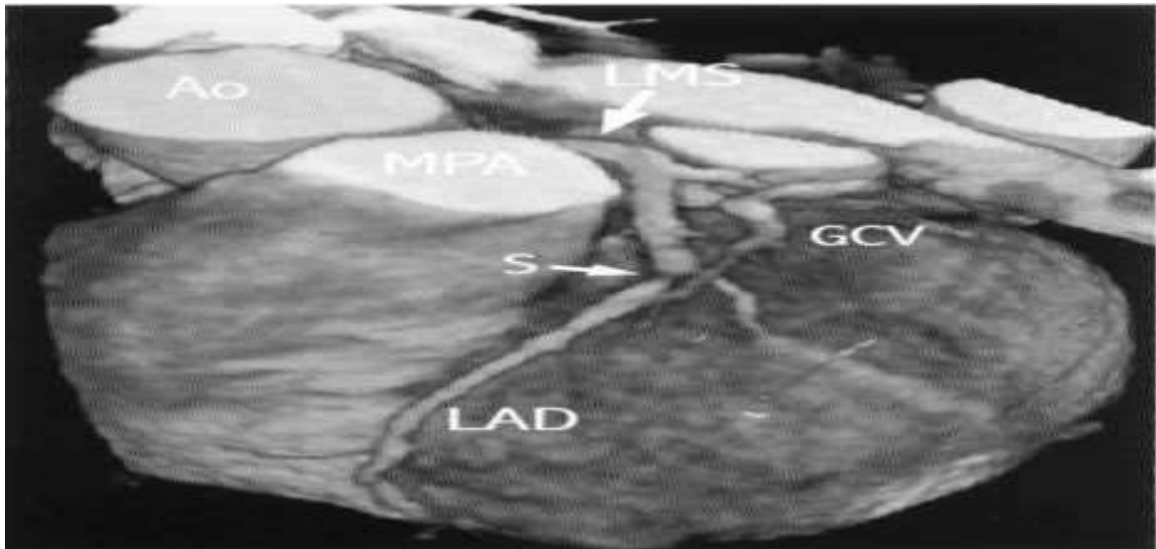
shows High-resolution multislice contrast CT demonstrating the left coronary artery with a stenosis (S) in the mid left anterior descending branch. Ao = aorta; MPA = main pulmonary artery; LMS = left main stem; LAD = left anterior descending artery; GCV = great cardiac vein.
